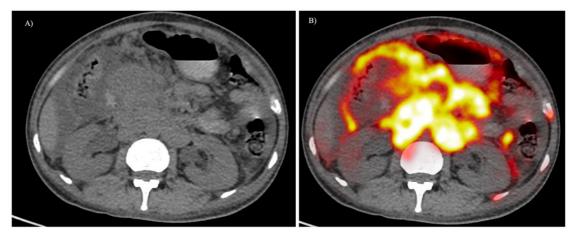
Non-contrast CT and PET/CT of the same patient in figure 14 showing retroperitoneal mass with FDG uptake.
